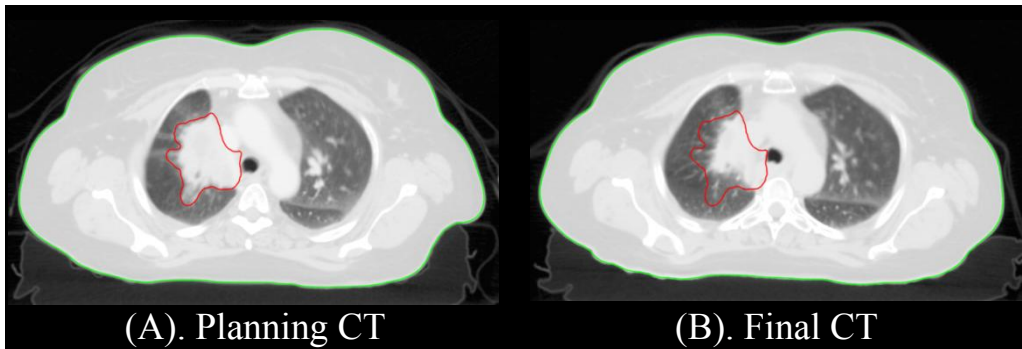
Example of tumor shrinkage observed between the planning CT (A) and the CT acquired at the last treatment session (B). The GTV and the body contour is colored red and green, respectively
